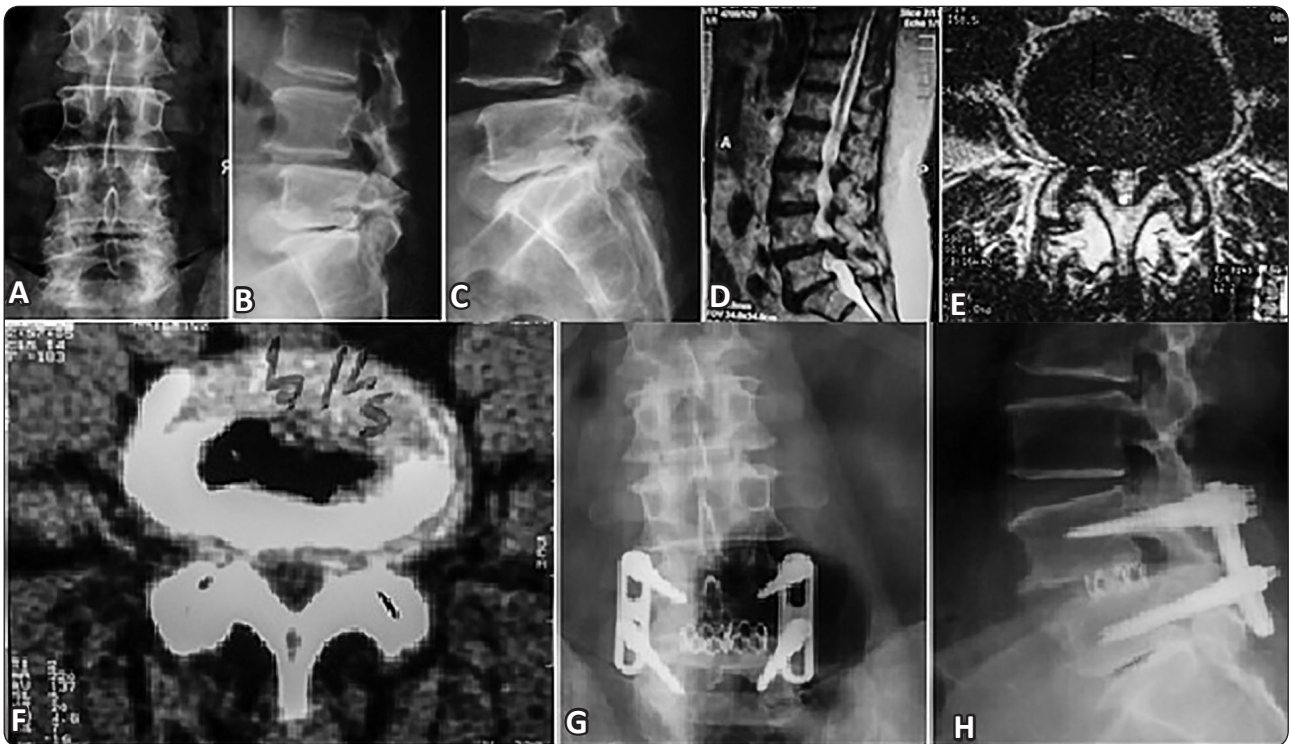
L4-5 degenerative spondylolisthesis treated by PLIF and transpedicular screws. (A,B,C) plain X-ray with dynamic films. (D,E) MRI T2WI sagittal and axial cuts. (F) C-T scan showing double egg shadows. (G,H) postoperative X ray with PLIF single Pyramid cage.
